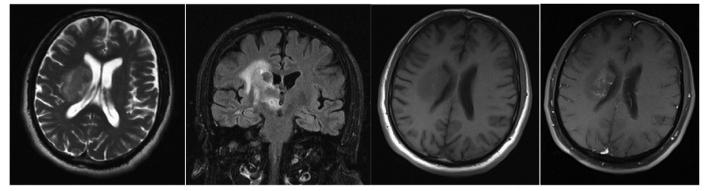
Pre-treatment magnetic resonance images of the patient. Left to right: T2 axial, flair coronal, T1 axial pre-contrast, T1 axial post-contrast
